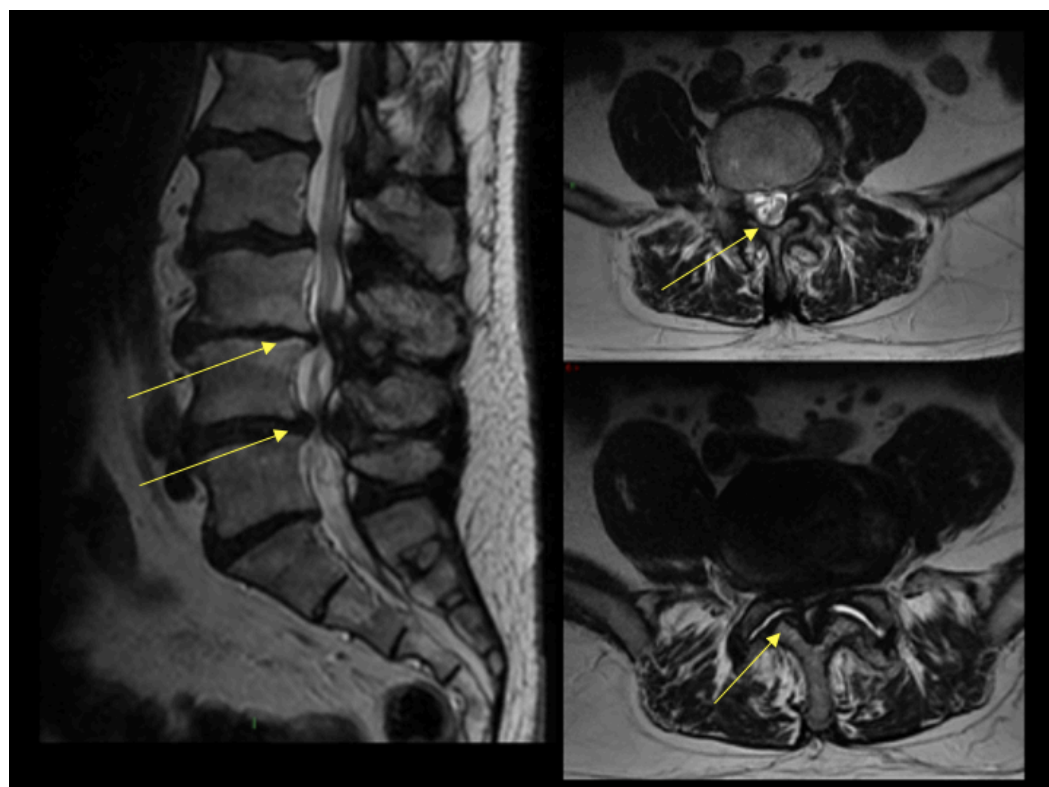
Sagittal T2 weighted MRI image depicting lumbar stenosis. Secondary to disc degeneration and spondylolisthesis where one vertebral body translates (slips) over an adjacent one. The arrows in the image on the left show multilevel stenosis, particularly severe at L3/4 and L4/5. The image on the top right shows axial images comparing a level with normal space for the lumbosacral nerve roots, indicated by the yellow arrow. In the bottom right axial image the ‘white’ cauda-equina syndrome (CES) is completely effaced causing severe stenosis, indicated by the yellow arrow. Images from the patient were anonymised and included in the publication with documented consent.
